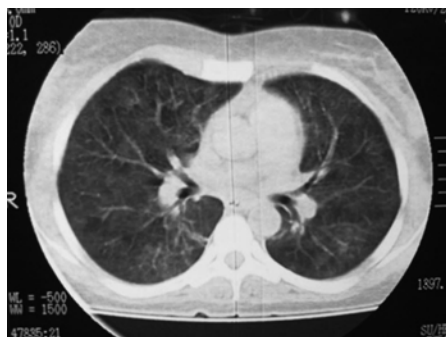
Diffuse ground glass opacity in both lungs on chest computed tomography scan four months before admission
